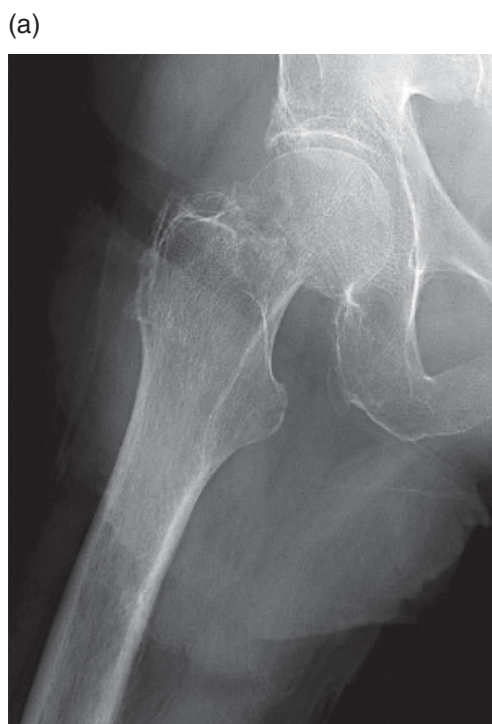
(a) An anteroposterior radiograph of a 94-year-old female with osteoporosis who sustained a right displaced femoral neck fracture after a fall. This patient was treated with a cemented hemiarthroplasty (b), given her limited functional status (ambulated only one block with a walker at baseline) and activity level.
